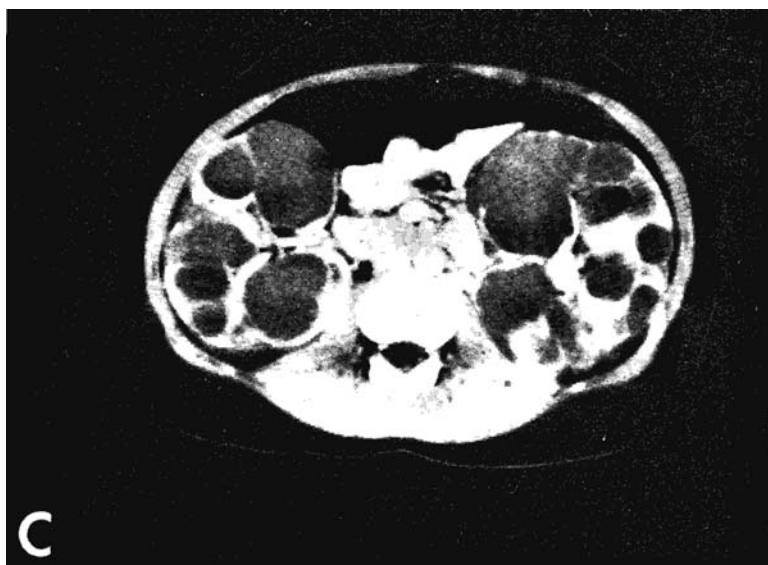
CT scan of ADPKD kidneys.
